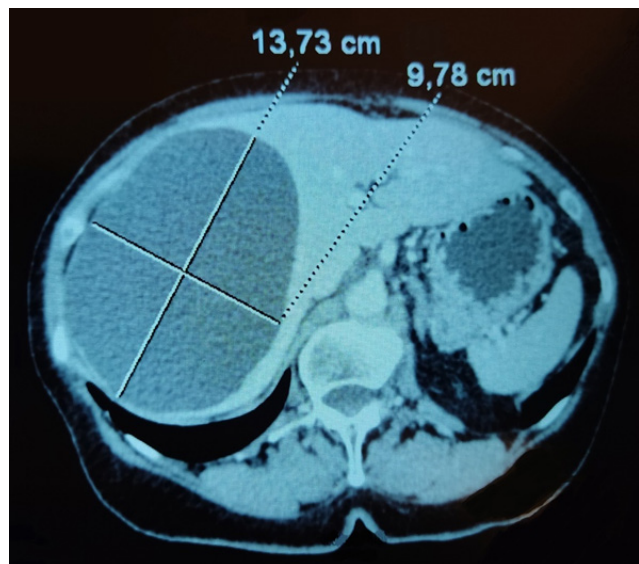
CT verified liver cyst
